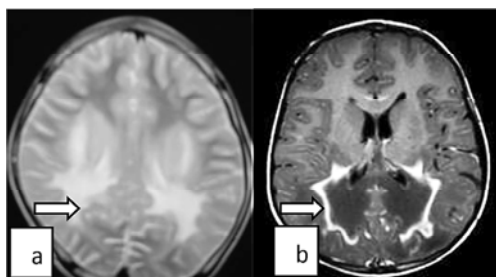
Adreno leucodystrophy Axial T2 MR image shows symmetrical white matter hyperintensities in the parieto occipital region b. Axial T1 contrast showing contrast enhancement
